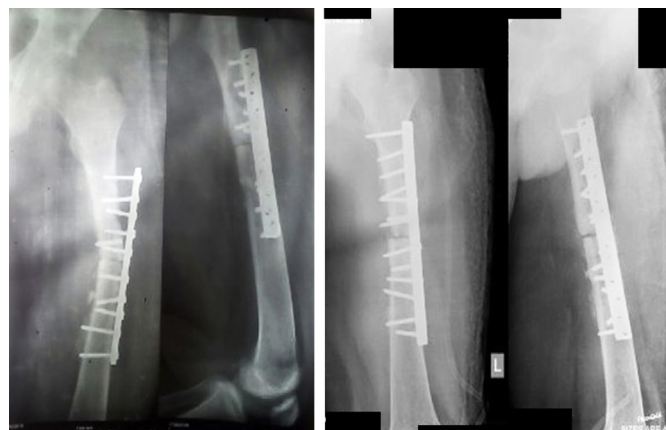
2nd implant Failure X-Ray (left) showed Proximal screws Pulled-out. 3rd postoperative X-Ray (right) showed ORIF revision surgery using longer plate. Both X-rays were taken 4 months after the second surgery
